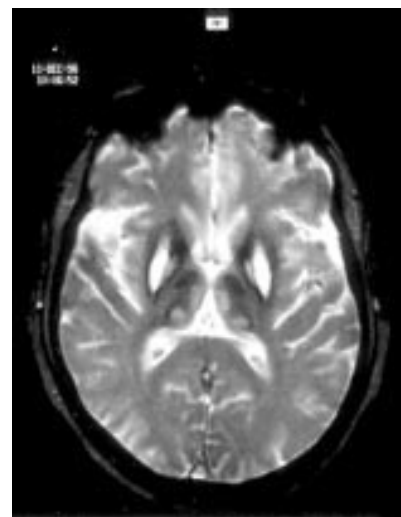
Magnetic resonance image of the brain showing hyperintensity on T2 weighting surrounding hypointensity on T2 weighting affecting the putamen, pallidum, and thalamus.
